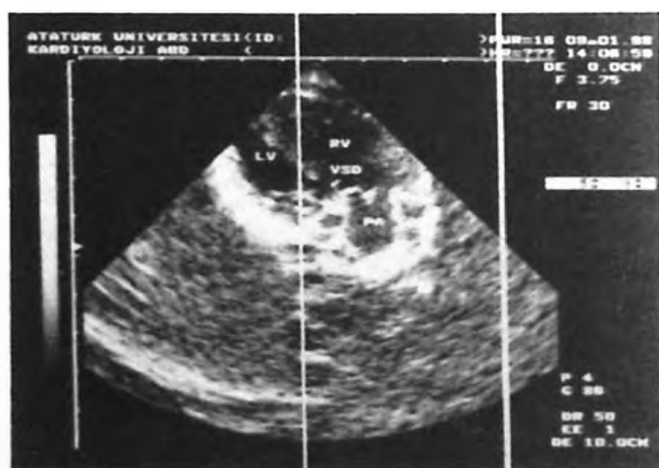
A two-dimensional echocardiogram (parasternal long axis) shows the double outlet right ventricle and subpulmonary ventricular septal defect (VS). RV: right ventricle, LV: left ventricle, PA: pulmonary artery, AO: aorta.
